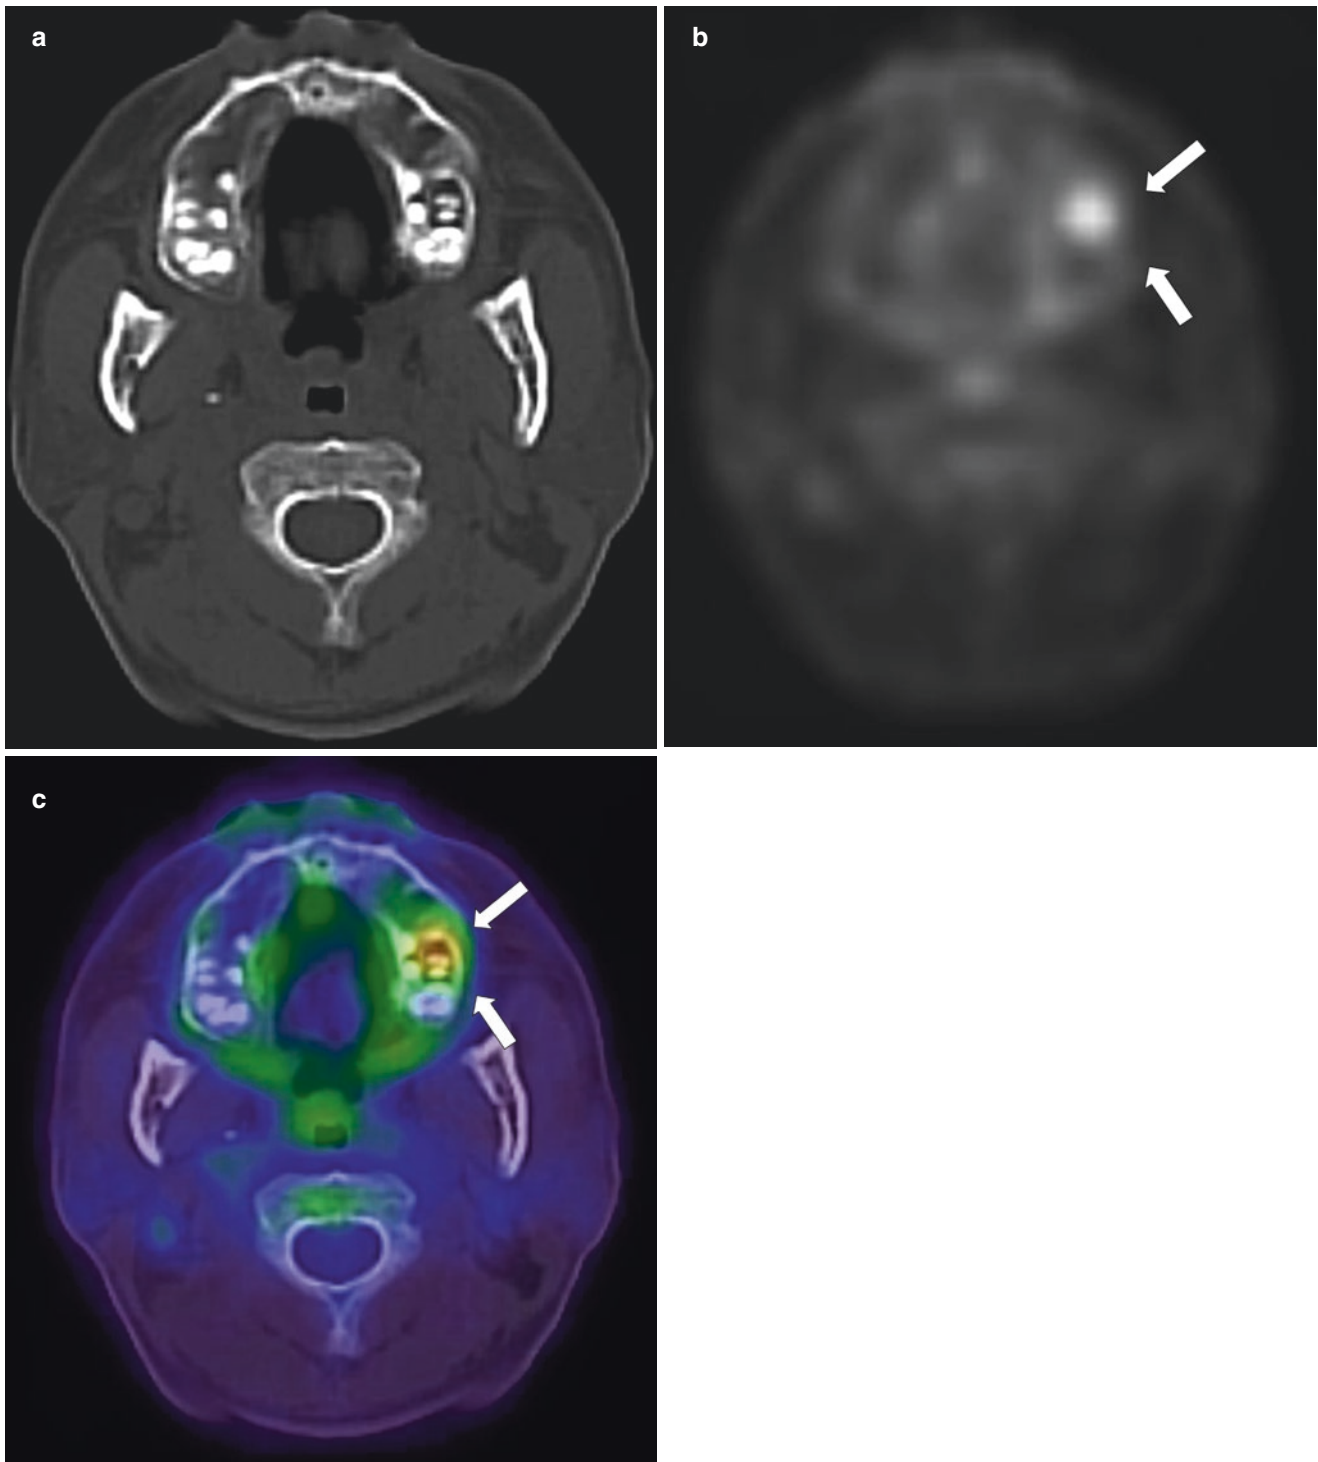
A 50-year-old man with nasopharyngeal carcinoma. CT in bone window, PET and fused images are presented (a, b and c). PET/CT showed nodular FDG uptake around tooth apices on the left side caused by dental infection (b and c, arrows)
